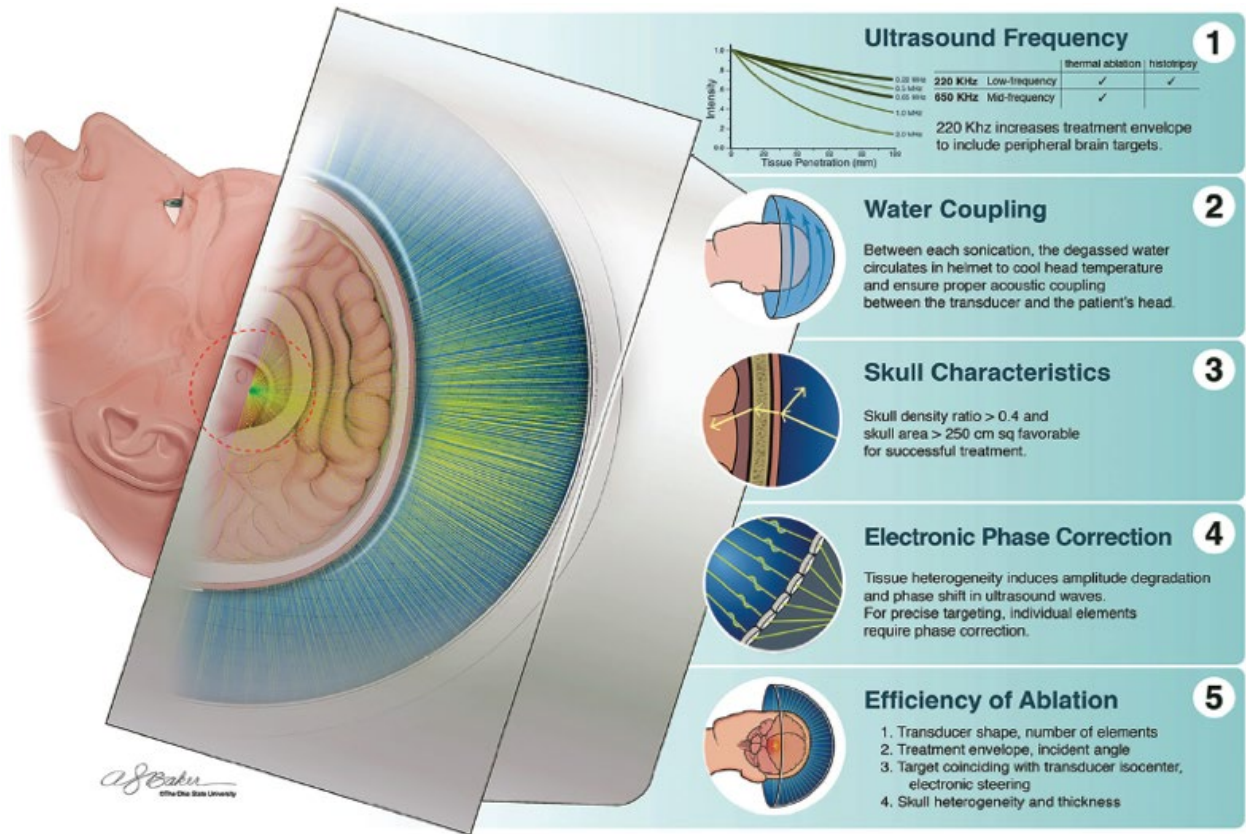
Shows how MRgFUS works by using ultrasound frequencies to burn the tremor out of the thalamus.
